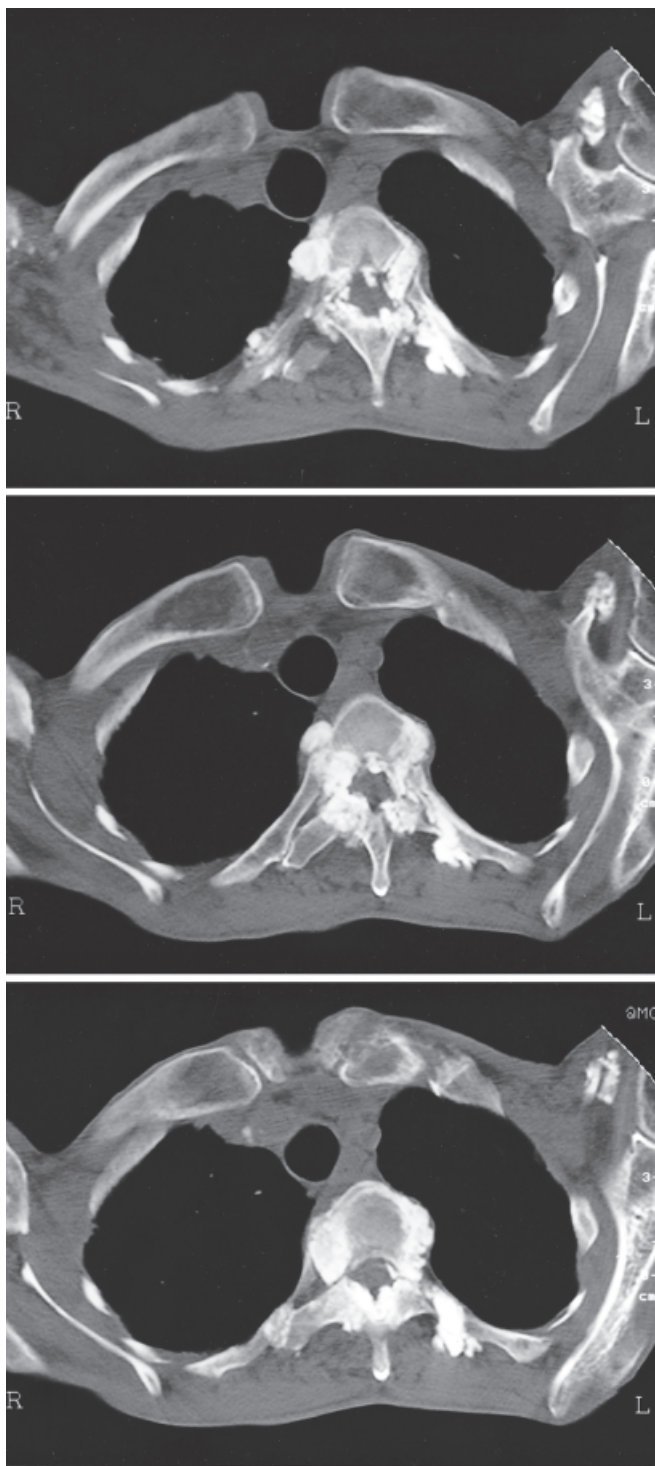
CT scan at the Th5–6 level after treatment, showing decreasing paraspinal and intraspinal calcific masses
